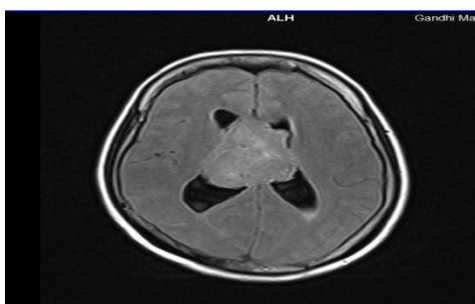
FLAIR (axial) and T₂W (axial) image showing hyperintense intraventricular lesion Central Neurocytoma
